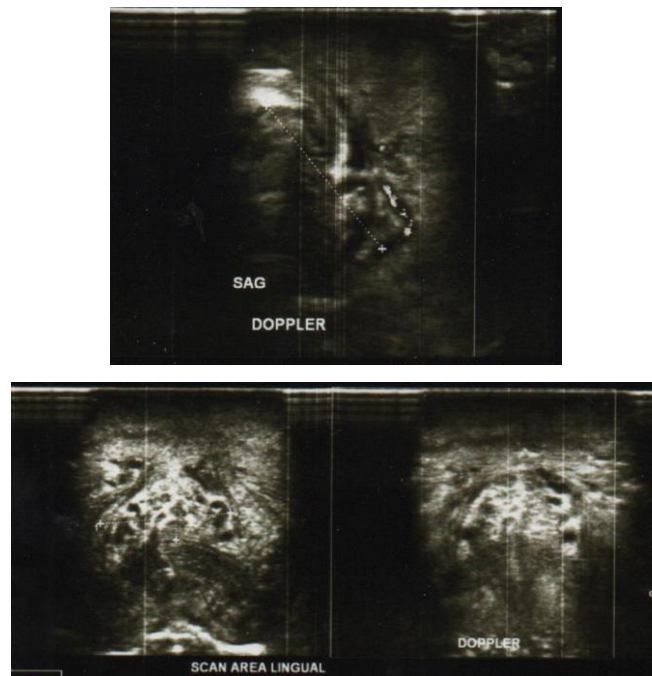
Ultrasonogram showed isoechoic inhomogeneous lesions with hypoechoic lesions within, lobulated, relatively clear borders, irregular, 1.9x0,96 cm in size and 2.12 cm in depth. Color Doppler did not show intralesional vascularization.
